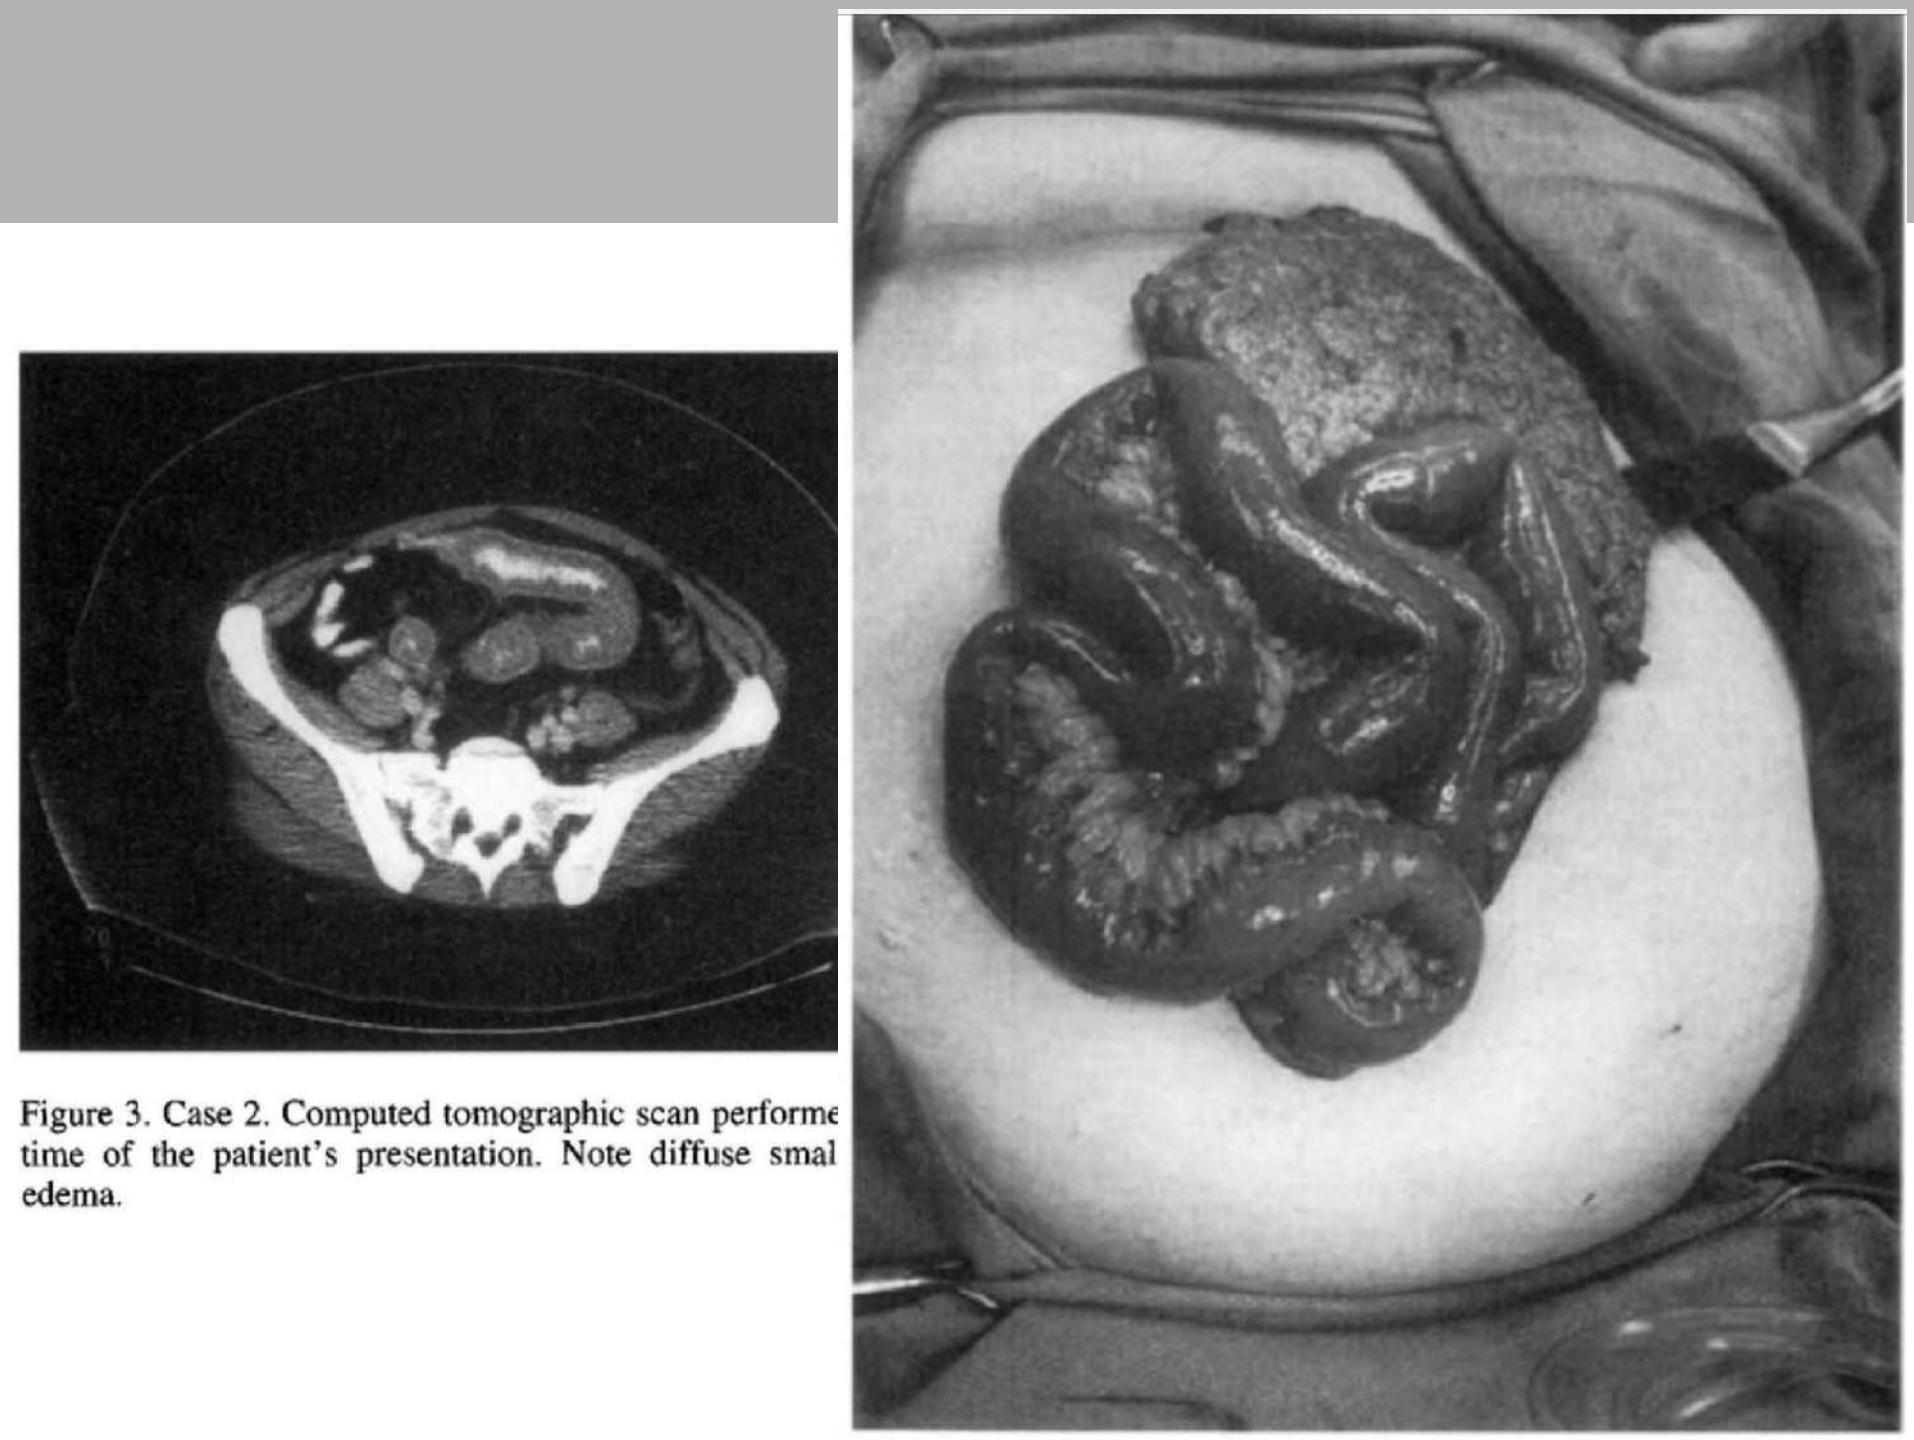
Case 2. Computed tomographic scan performed at time of the patient's presentation. Note diffuse small renal edema.
